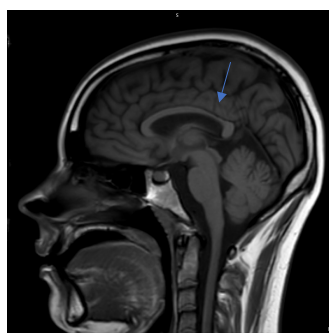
Sagittal T1-WI MRI shows partial congenital hypoplasia of the distal body of corpus callosum.
